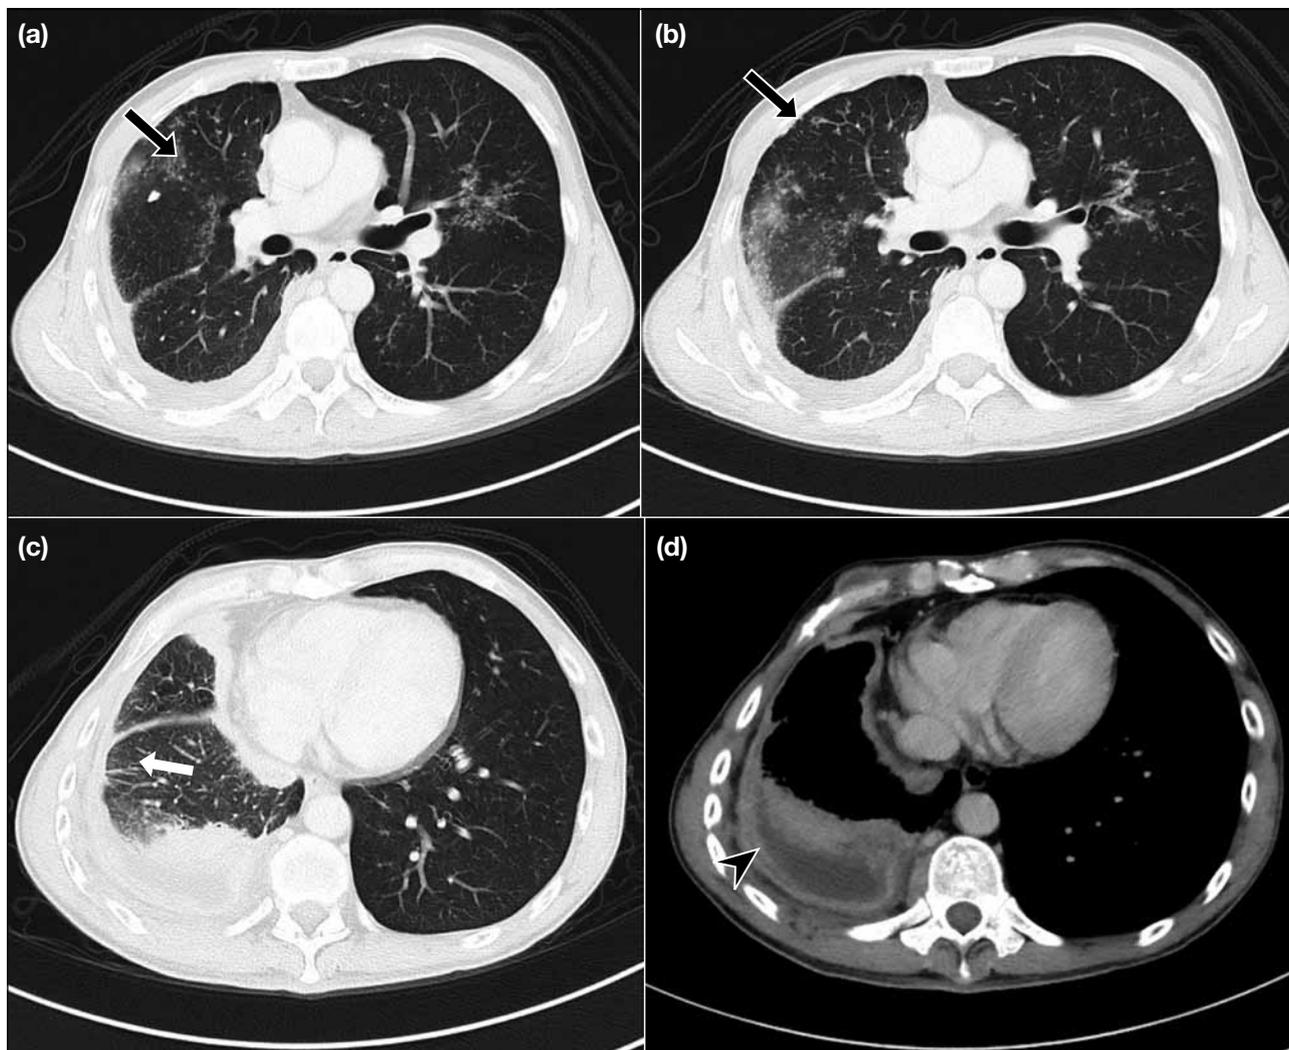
Contrast computed tomographic thorax: (a and b) multiple tree-in-bud nodules in right middle lobe and lingular segment (black arrows); (c) smooth interlobular septal thickening in the right lower lobe (white arrow); (d) encysted right pleural effusion (black arrowhead).
